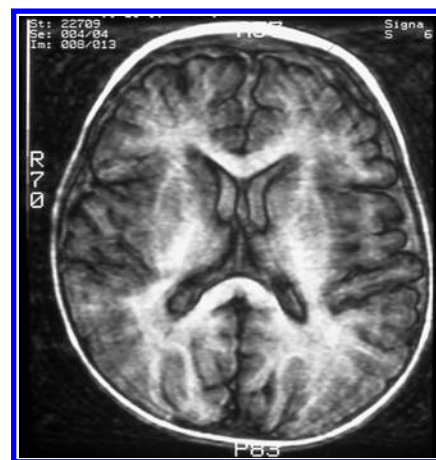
Abnormalities in the basal ganglia and white matter disease on T_2 -weighted magnetic resonance images.
